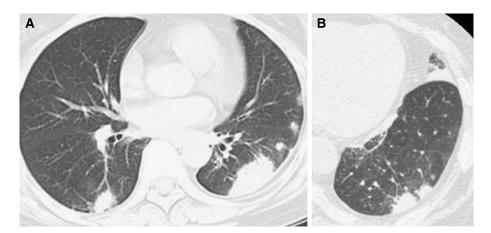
Cryptococcosis*. *Cryptococcosis* in a 71-year-old woman with cough who had been treated with bucillamine for 2 years. (A) Computed tomography (CT) and (B) high-resolution CT, showing multiple subpleural nodules and/or consolidation in the lower lobes that mimic cryptogenic organizing pneumonia. The patient's symptoms and radiologic abnormalities resolved after institution of fluconazole therapy.
